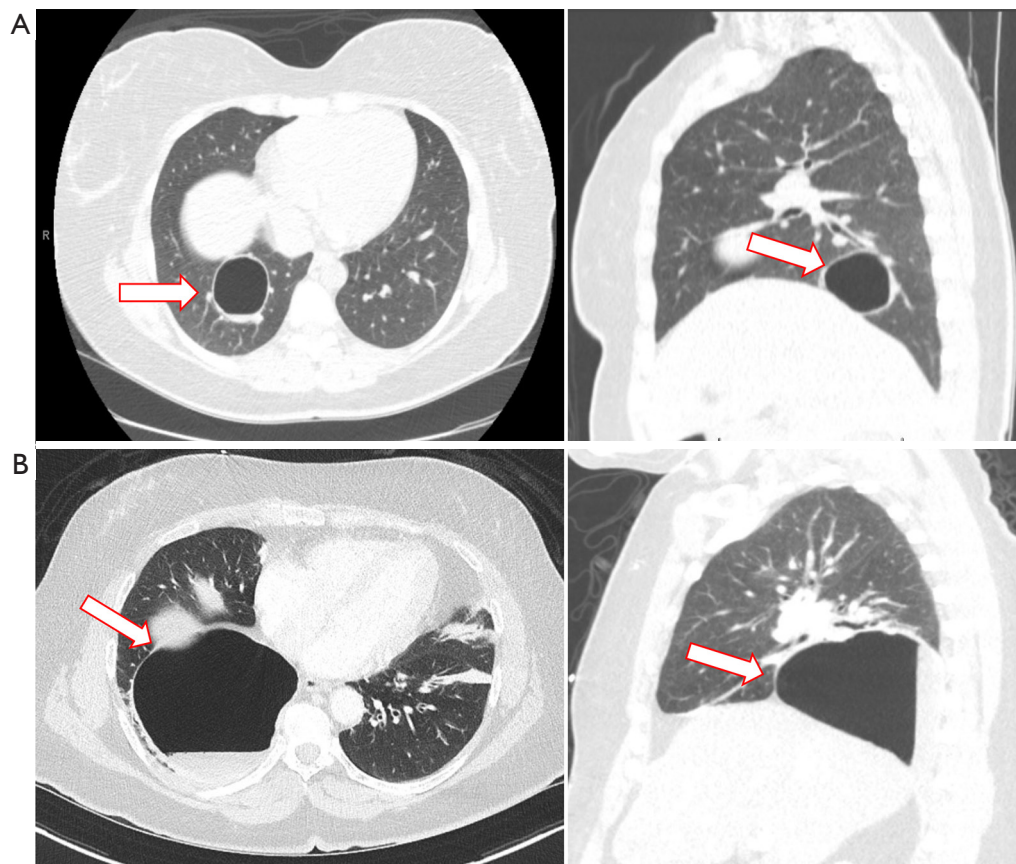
Intraparenchymal bronchogenic cyst. (A) Axial and sagittal images of a chest CT scan with intravenous contrast of a 34-year-old woman demonstrating a large peripherally located cyst in the right lower lobe, adjacent to segmental pulmonary vessels. She had a history an enlarging cystic lesion once complicated by an infection that was treated with a month-course of oral antibiotic. A complete resection was achieved by right robotic thoracoscopy and enucleation of the lung cyst separating the cyst wall from the underlying vessels and bronchus thus avoiding a pulmonary segmentectomy. Pathologic examination determined this lesion being a benign bronchogenic cyst. Red bordered arrow marks the cyst. (B) Axial and sagittal cuts of a CT scan with intravenous contrast of a 63-year-old woman admitted to the hospital with fever/chills and leukocytosis showing a cystic lesion in the right lower lobe with air-fluid level suggestive of an infected intrapulmonary bronchogenic cyst. This was her first presentation of a bronchogenic cyst. The cyst was completely resected by a right robotic thoracoscopy and wedge resection of the cyst. Final pathology report shows: Respiratory-lined cyst with fibrosis, adjacent fibrinopurulent exudate, granulation tissue and reactive mesothelial hyperplasia. Red bordered arrow marks the cyst. CT, computed tomography.
